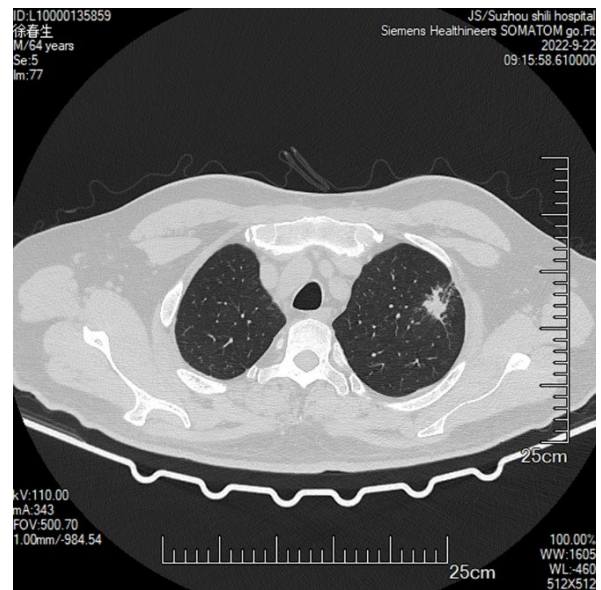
65 were lobulated signs which were indicated by CT.
